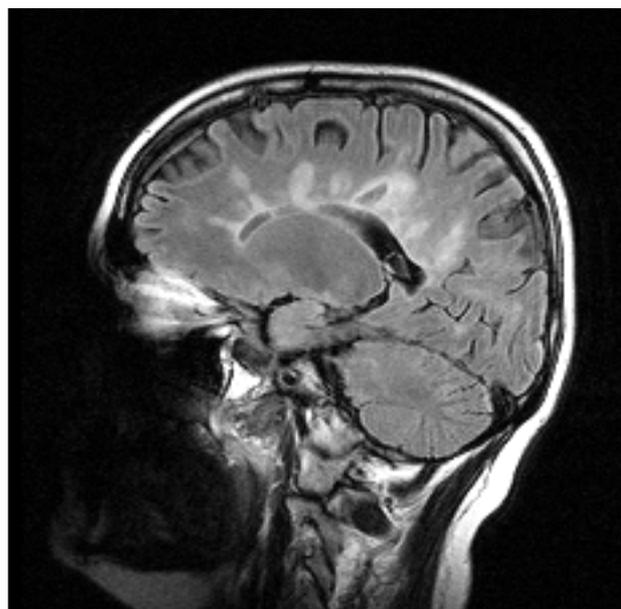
Demyelinating lesions in the sagittal Flair MRI scan.
